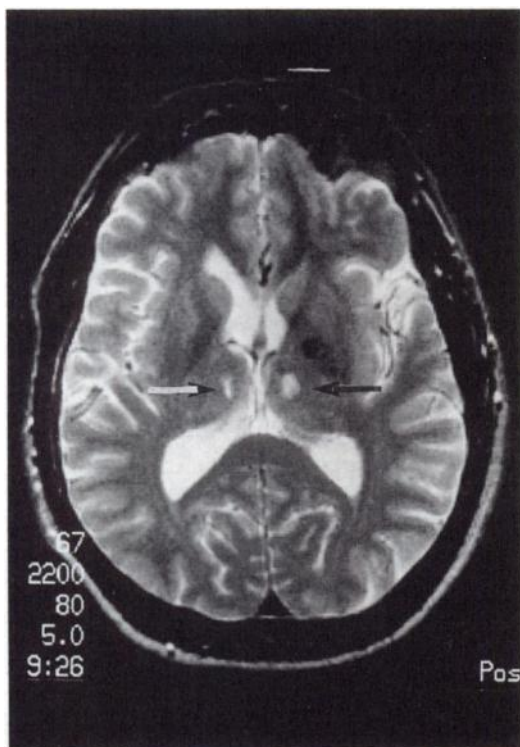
Brain CT scan showing bilateral thalamic infarction.
